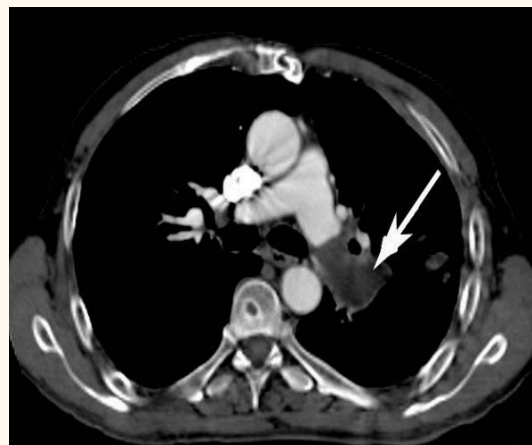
Multidetector computed tomography angiography shows hypodense masses located in the left main pulmonary artery (white arrow) and in the left distal pulmonary artery to the segmentary branches of the upper lobe.
